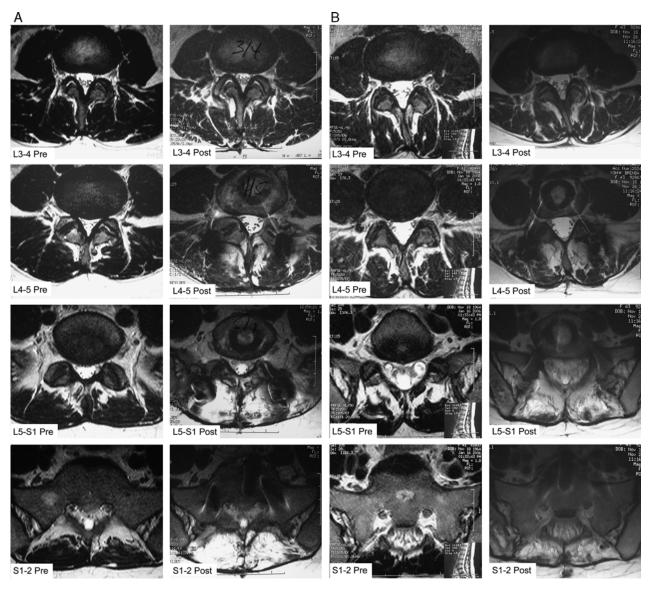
Examples of lumbar MRI axial images from proximal to distal levels (L3–L4, L4–L5, L5–S1, and S1–S2) with increased region of T2 posterior muscle signal intensity on postoperative images (right). A, Representative images for a midline approach patient (42 y old female). B, Representative images for a paraspinal approach patient (42 y old female).
